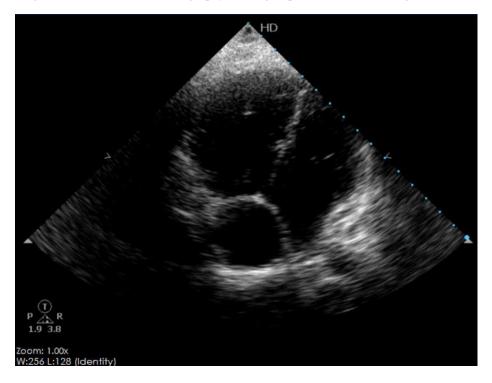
Transthoracic echocardiography showing right heart free of thrombus after thrombolysis
